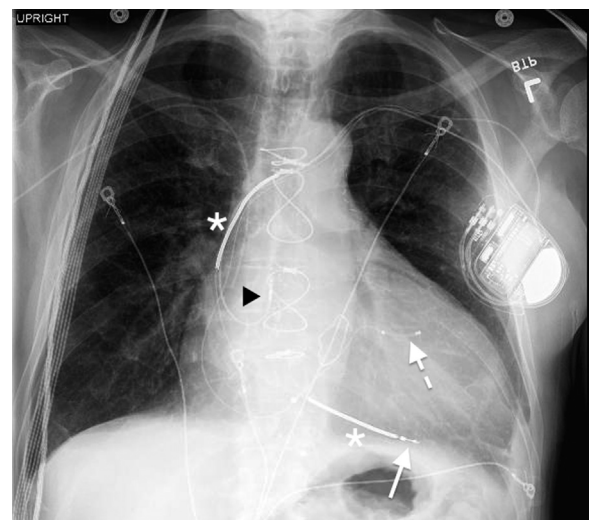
Upright frontal chest radiograph demonstrating a cardiac resynchronization therapy-D device. A cardiovascular implantable electronic device with supraventricular/ventricular shock coils (asterisks) and a bipolar pacing lead in the right ventricle (solid arrow), an atrial lead in the right atrium (black arrowhead), and a coronary sinus lead (dashed arrow) for biventricular pacing.
